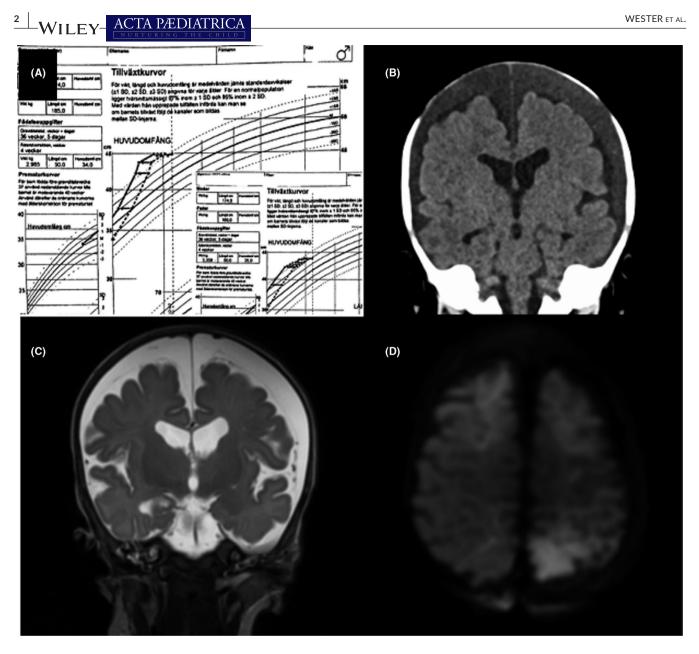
(A) Twin 1 and 2. Head circumference (HC) charts for both twins. Left, larger chart: twin 1. Lower right—inserted smaller chart: twin 2. Stippled lines: HC development since birth. Solid lines: HC adjusted for age. First thin vertical line indicates three months of age. (B) Twin 1. Coronal computed tomography scan obtained shortly after admission, with bilateral low-attenuating subdural fluid compatible with chronic subdural haematoma (chronic SDH), but a preserved subarachnoid space and non-compressed cortex. The interhemispheric width is larger than normal. (C-D) Images from MR examination two days after admission. Coronal T2 weighted image (C), clearly shows wide subarachnoid spaces despite the overlying chronic SDH, compatible with benign external hydrocephalus. Diffusion-weighted image (D) shows left-sided parietal and bilateral superior frontal hypoxic/ischaemic lesions
